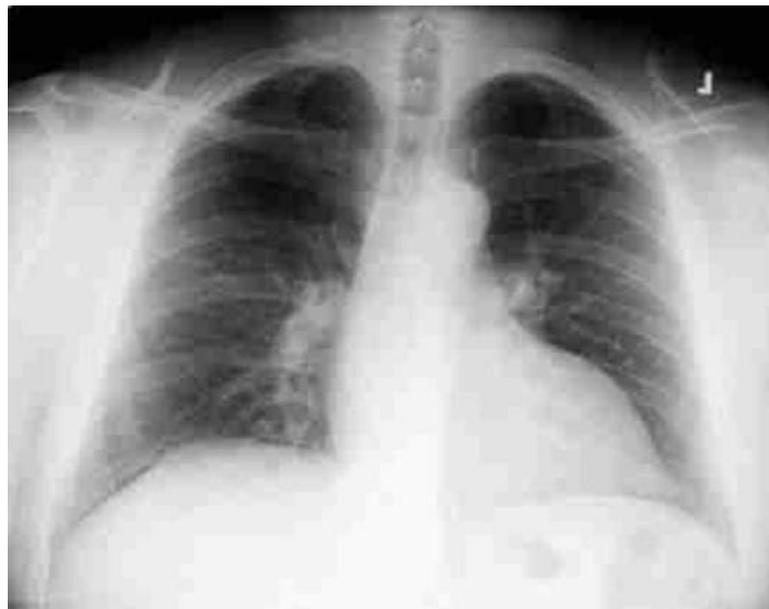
A chest radiograph with normal findings in a 64-year-old woman who presented with worsening breathlessness.
